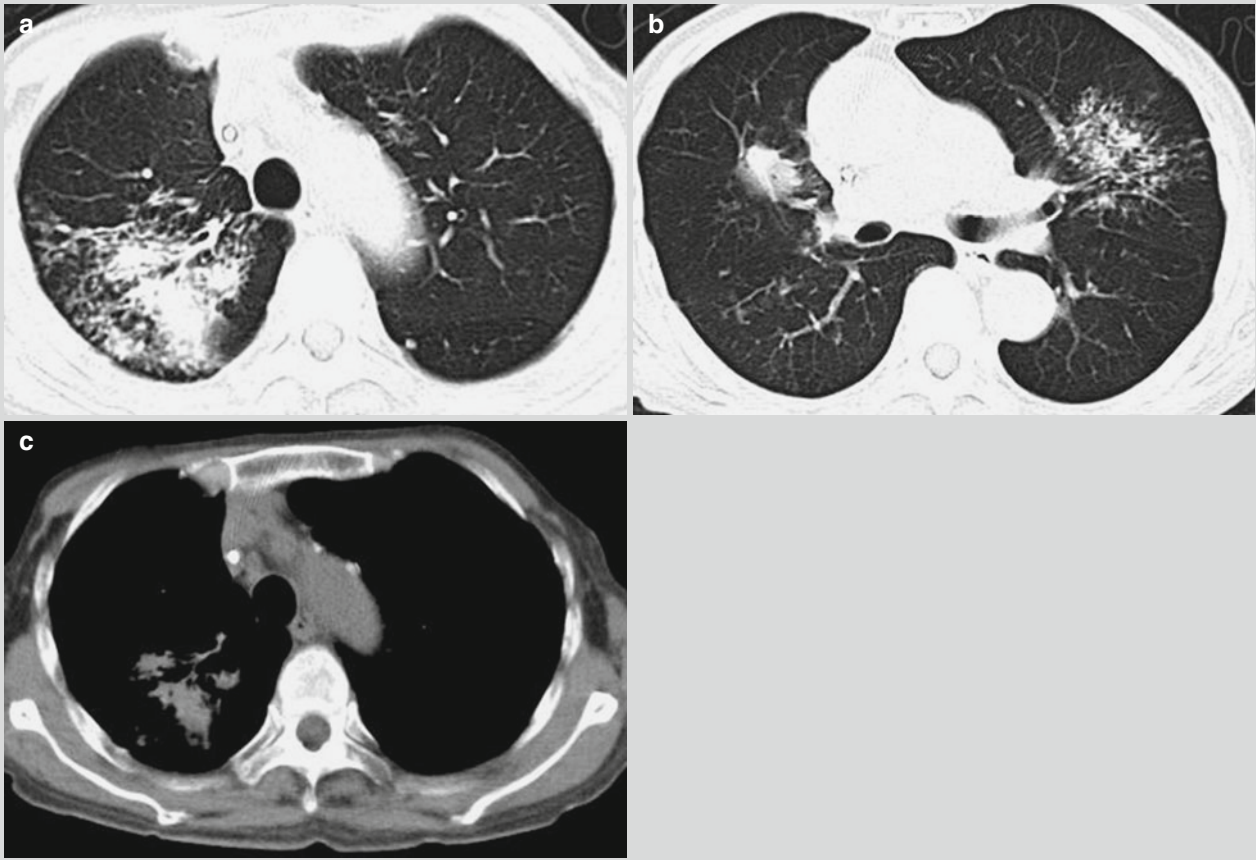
Infiltrative pulmonary TB. (a–c) CT scanning demonstrates flakes and nodular blurry shadows at both lungs, dilation of local bronchial lumen, thickening of local bronchial wall, and calcification of some lymph nodes
